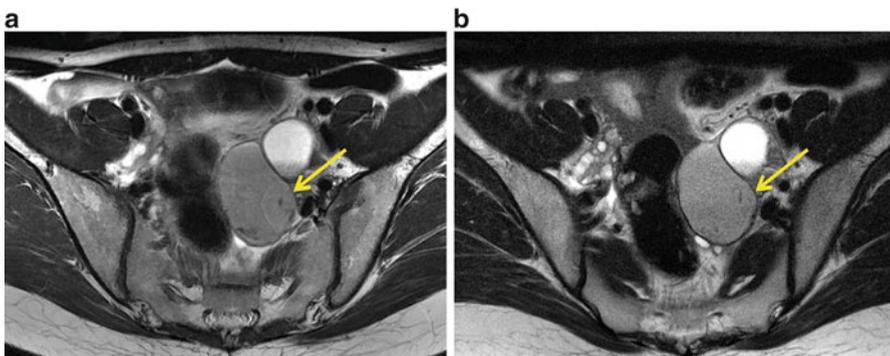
A 32-year-old woman with left ovarian endometriotic cyst. Axial T2-weighted images demonstrate left ovarian hypointense cystic mass (arrow). The shading sign is more prominent at 3 T (a) than at 1.5 T (b)
